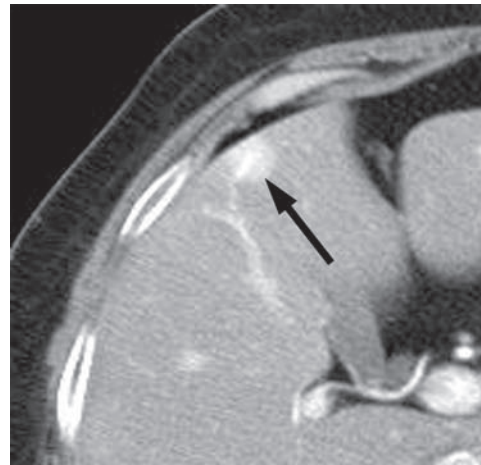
Nontumoral arterioportal shunt in a 45-year-old man with liver cirrhosis. Arterial phase CT scan shows a wedge-shaped area of high attenuation with an internal branching structure (arrow).
